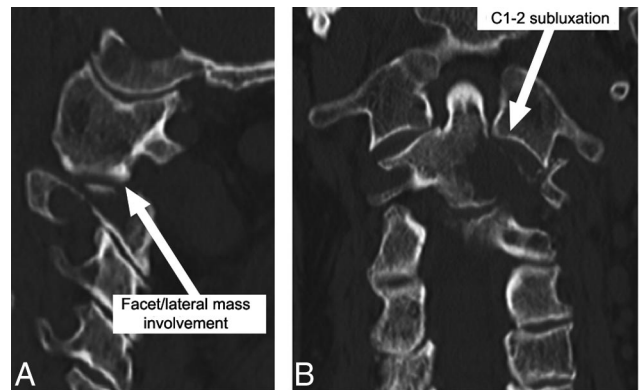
A, Sagittal computed tomography (CT) scan demonstrating lytic lesion of the left C2 lateral mass with pathologic fracture and C1–C2 subluxation. B, Coronal CT scan demonstrates extent of lytic lesion and subluxation of left C1–C2 articulation through the pathologic fracture.
